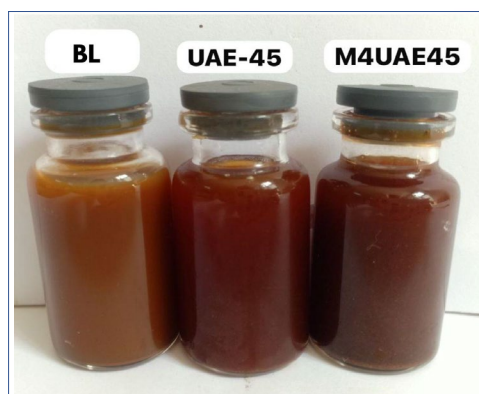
Filtrates obtained from different extraction methods: (A) boiling for 30 minutes (BL), (B) ultrasonic-assisted extraction for 45 minutes (UAE45), and (C) microwave-assisted extraction for 4 minutes followed by ultrasonic-assisted extraction for 45 minutes (M4UAE45).
